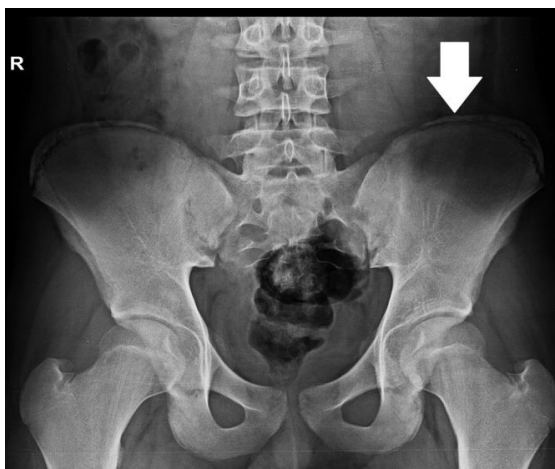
Xray pelvic anteroposterior view of 15 years old boy with Risser's sign Grade IV where iliac apophysis is extending from lateral to the medial side up to the spinal extent (vertical white arrow).
